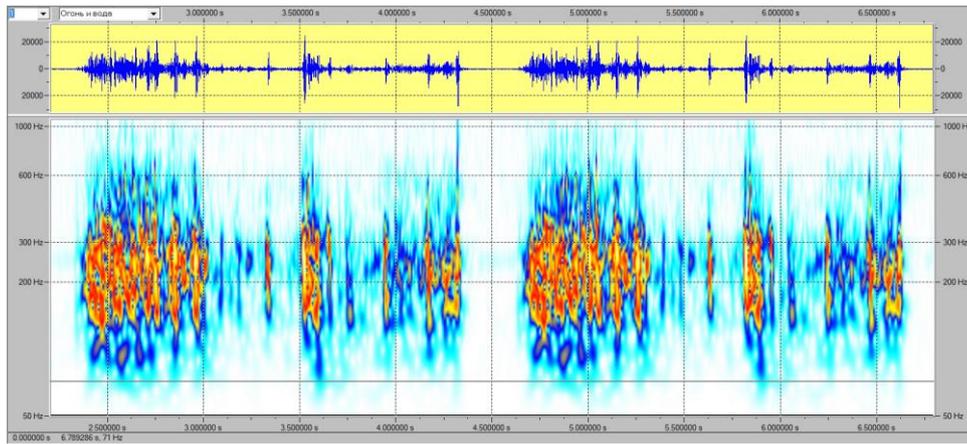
Acoustic sonogram of sound is a rough noise of friction of the patient's pleura against the background of vesicular respiration. Frequency range 71-800 Hz
